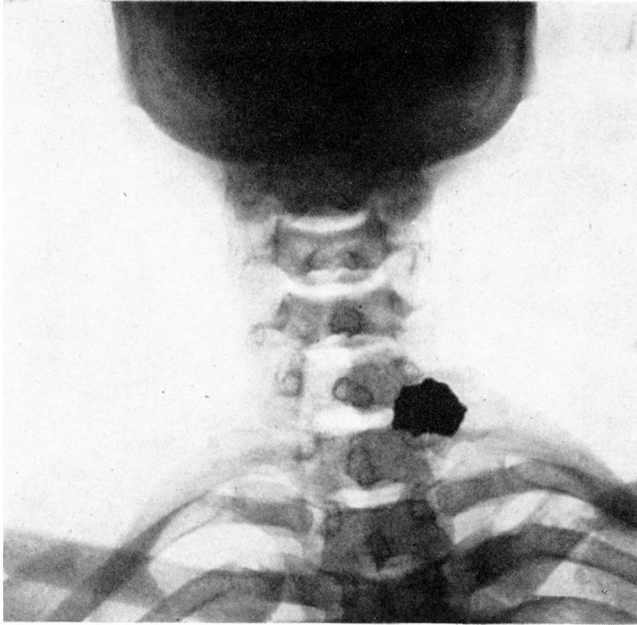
Anteroposterior roentgenogram.
